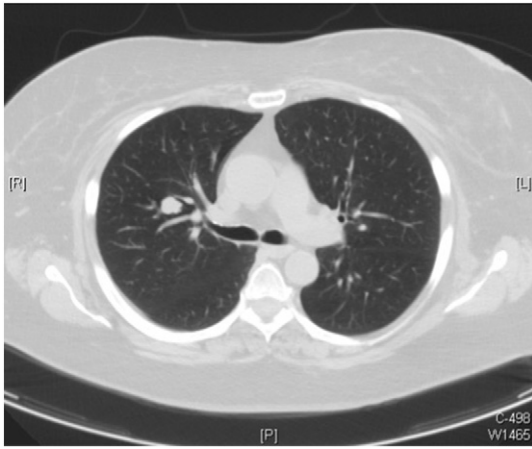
CT scan of the chest revealing a right upper lobe nodule measuring 13 mm × 12 mm.
